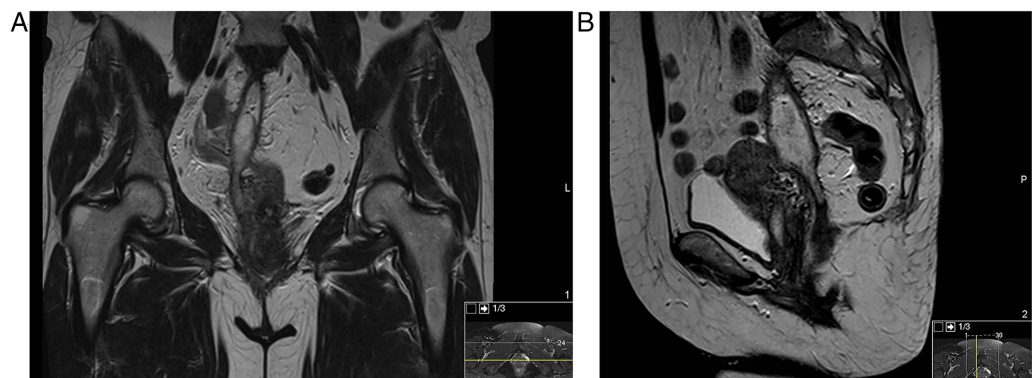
Abdominopelvic MRI with contrast: right fistulous tract from vagina communicating with a retroperitoneal abscess that extends up to the promontory level (A: coronal plane; B: sagittal plane).
